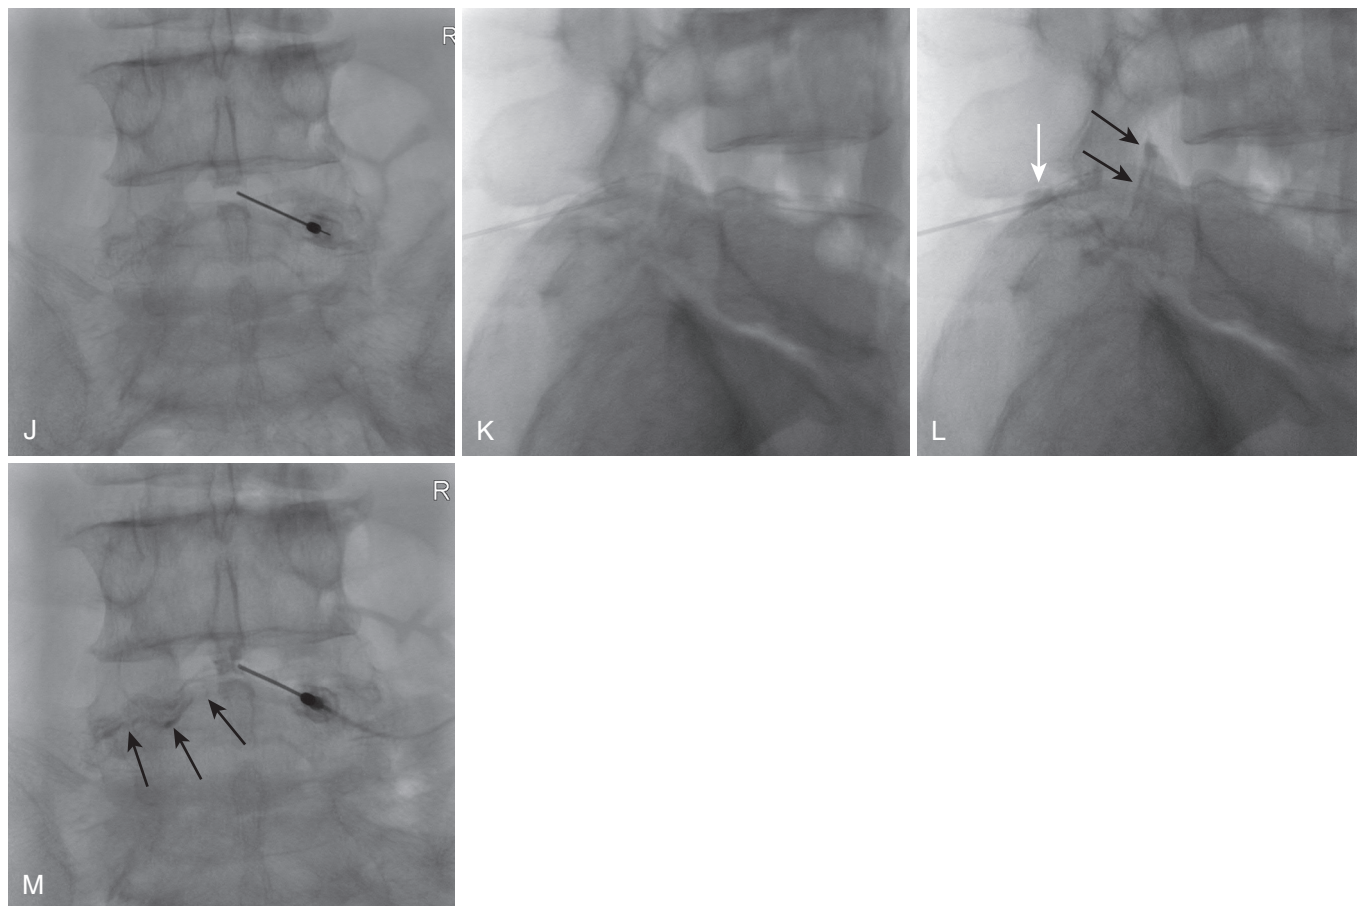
cont'd. In a final patient, an attempted interlaminar injection (needle placement images J, K) opacified the interspinous ligament (*white arrow* in [L]) and the left L4-5 facet (*black arrows* in [L]) via the space of Okada. This space (*black arrows* in [M]) is posterior to the ligamentum flavum; the needle was advanced ventrally into the epidural space without incident. (From Murthy NS, Maus TP, Aprill C. The retrodural space of Okada. *AJR Am J Roentgenol.* 2011;196:W784-W789.)
